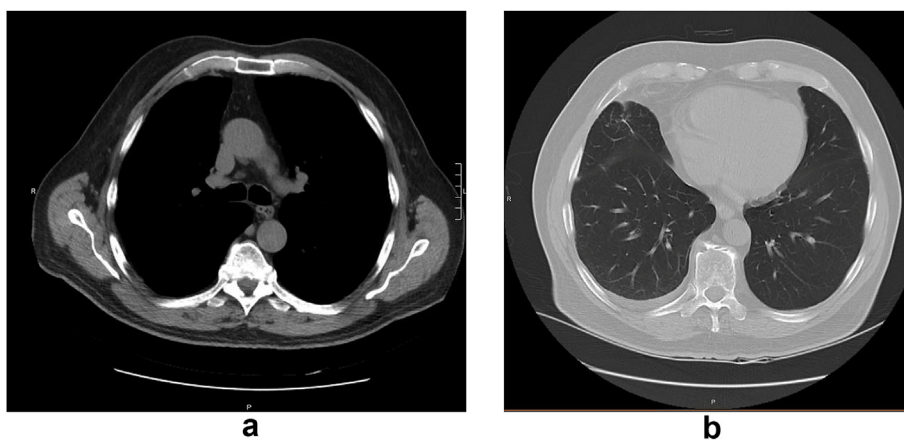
CT scan showed regression of lymphadenopathy and near complete resolution of pleural effusion.
